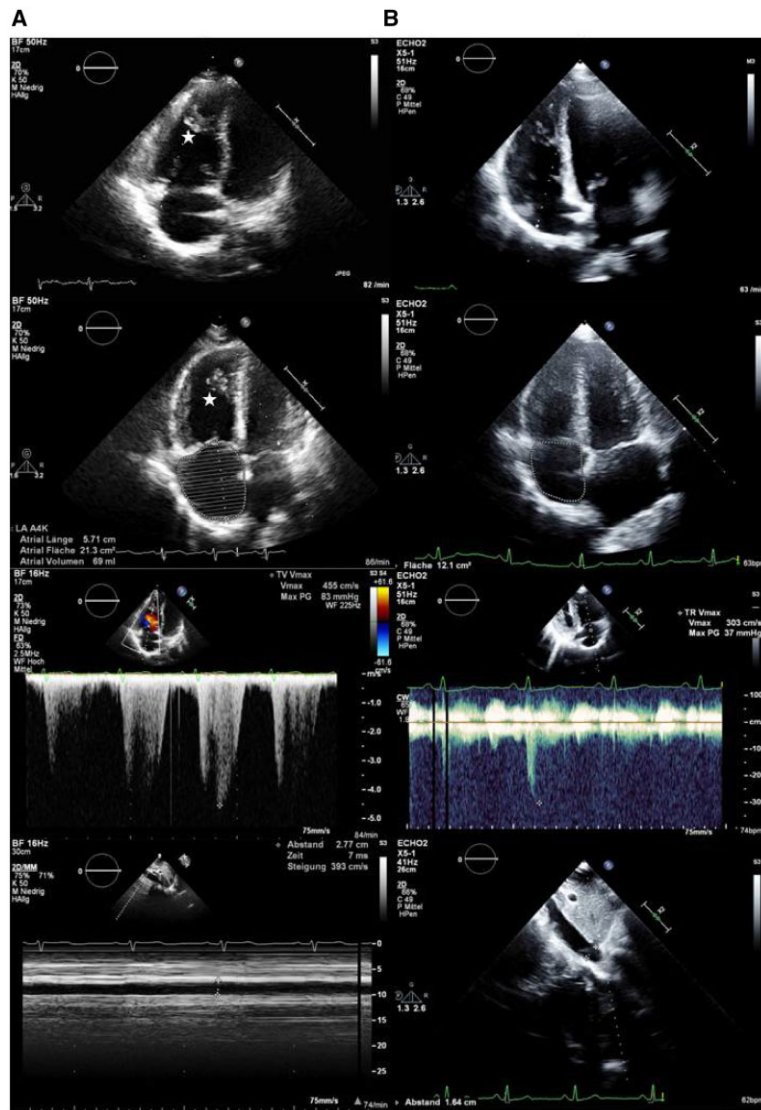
Transthoracic echocardiogram with echo studies before treatment initiation (column A) and after treatment initiation with calcium channel blocker and endothelin receptor antagonist (column B). First row showing right ventricle size, 2nd row showing right atrium size, 3rd row showing the gradient derived from maximum velocity of tricuspid regurgitation for estimation of systolic PA pressure (note that in 3B transducer orientation is rotated 180 degree showing right ventricle on the right side), 4th row showing the size of the inferior caval vein. ★: Prominent moderator band in the right ventricle.
